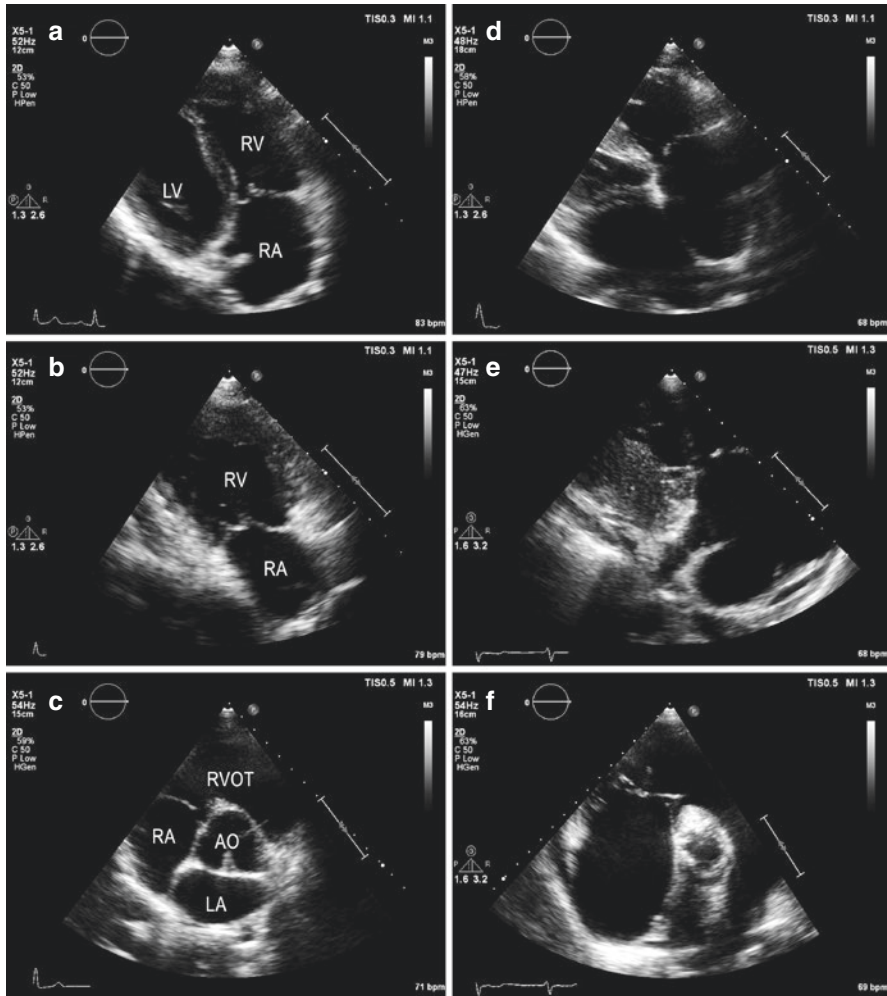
The parasternal 2D-TTE views: standard right ventricular inflow tract view from a normal subject (a) and after further angulation (b) to exclude left ventricle from the scan sector and a standard parasternal short-axis view at base of the heart (aortic valve) level (c). Corresponding views from a patient with an abnormal TV (d, e and f). *LV* left ventricle, *RV* right ventricle, *RA* right atrium, *RVOT* right ventricular outflow tract, *LA* Left atrium, *AO* aorta
